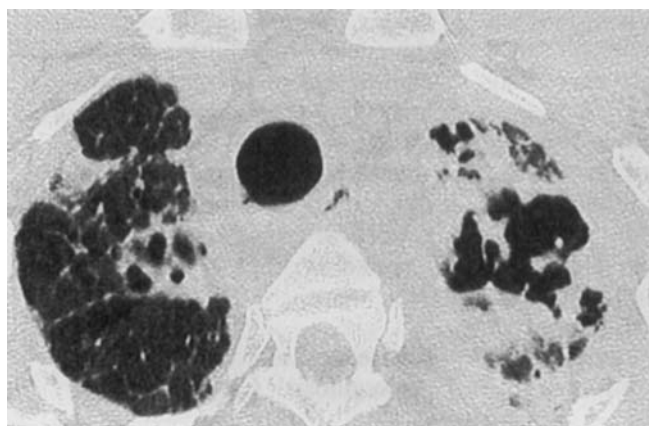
HRCT of the chest showing a left apical cavity with consolidation and fissuring of the tracheal wall consistent with fungal disease
